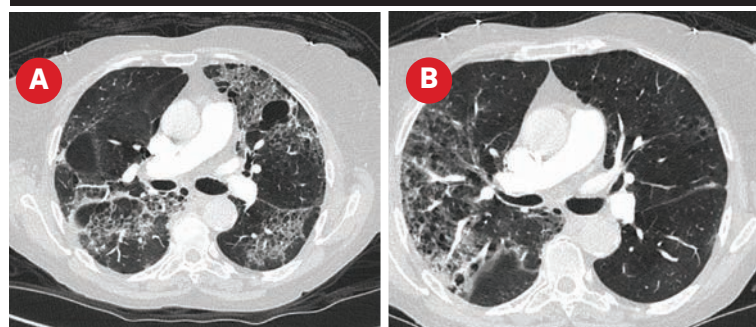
Progress CT. Figures 5A and 5B. CT with peripheral areas of consolidation consistent with organising pneumonia.
